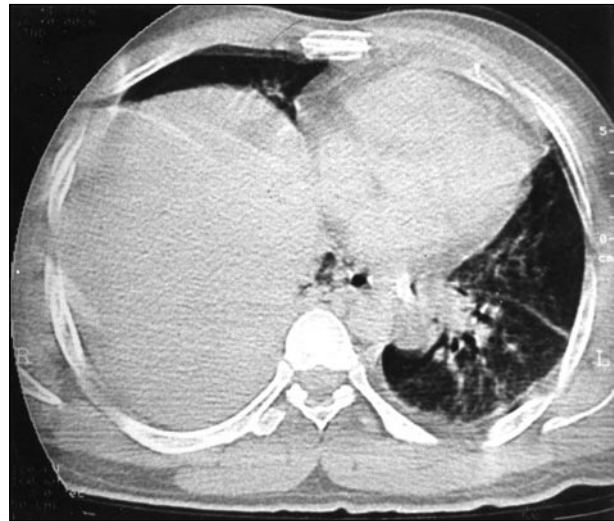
CT-scan showing complete liver herniation into the right pleural space.
